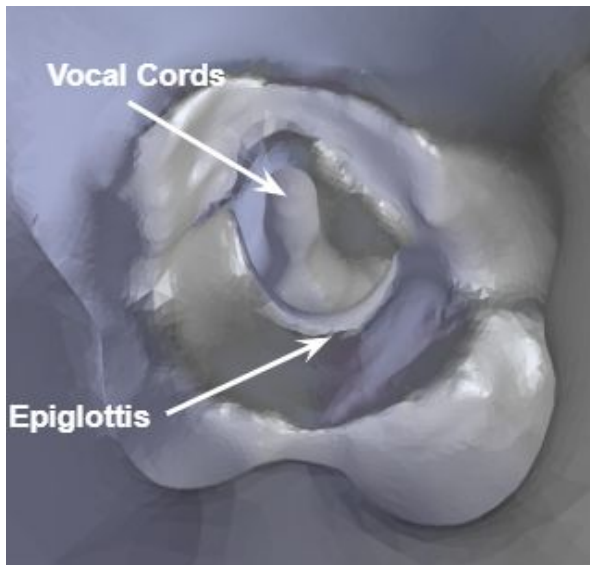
The inner anatomy after refining the initial CT-model.
